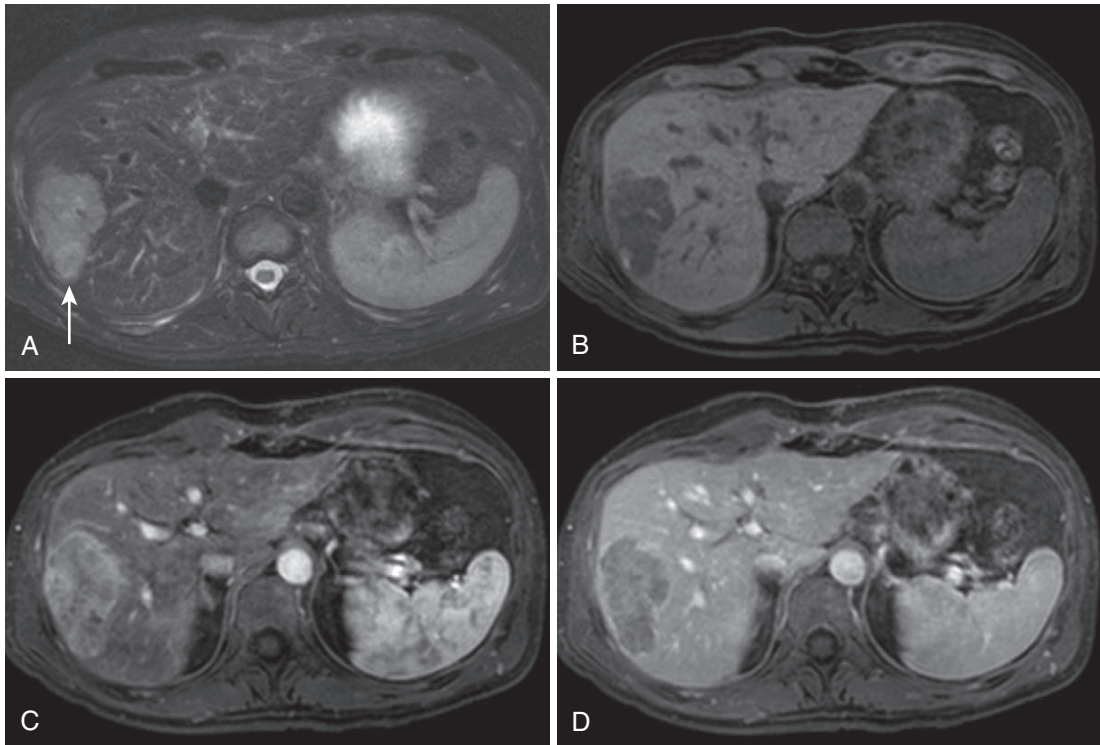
Hypervascular metastasis. The moderately T2-weighted image (A) shows a hyperintense uveal melanoma metastasis in the right lobe of the liver (*arrow* in A), which is hypointense on the corresponding precontrast T1-weighted image (B), enhancing avidly on the arterial phase image (C) and washing out on the delayed image (D).
